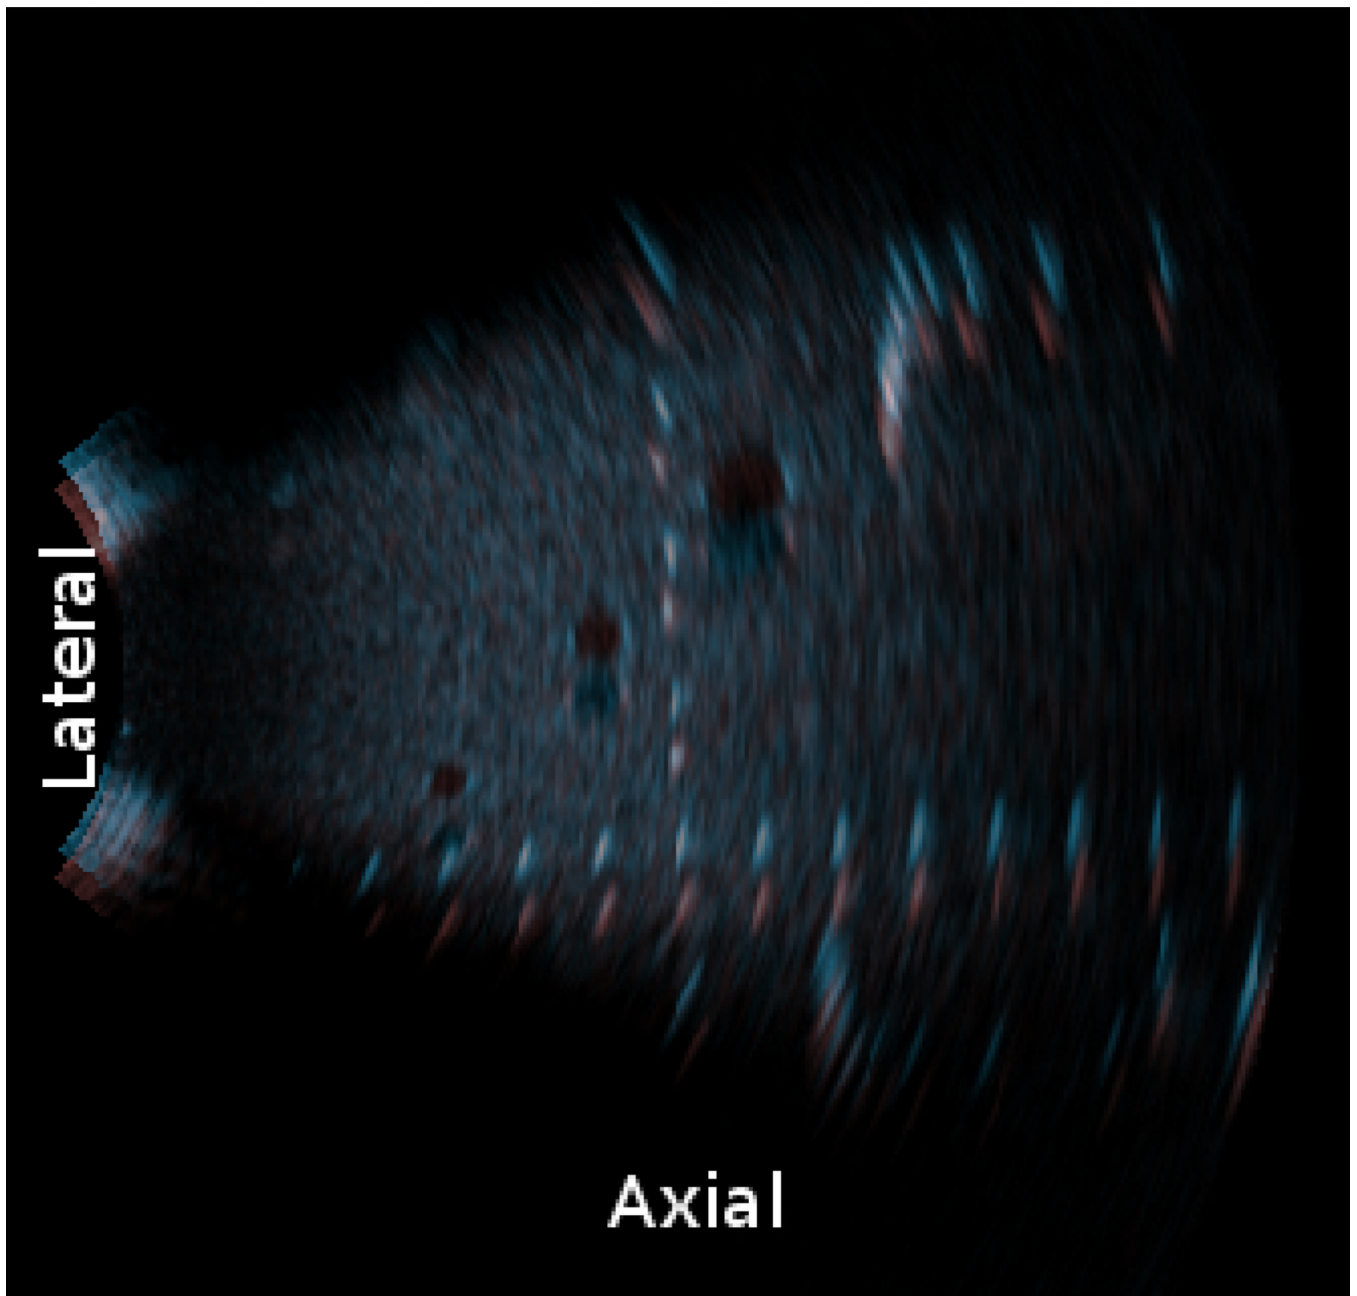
3D flow vectors computed using the variational method on ultrasound data that has been synthetically laterally deformed by 6% (i.e.,  $\alpha = 1.06$ ,  $\beta = \frac{1}{1.06}$ , and  $\gamma = 1$ )
